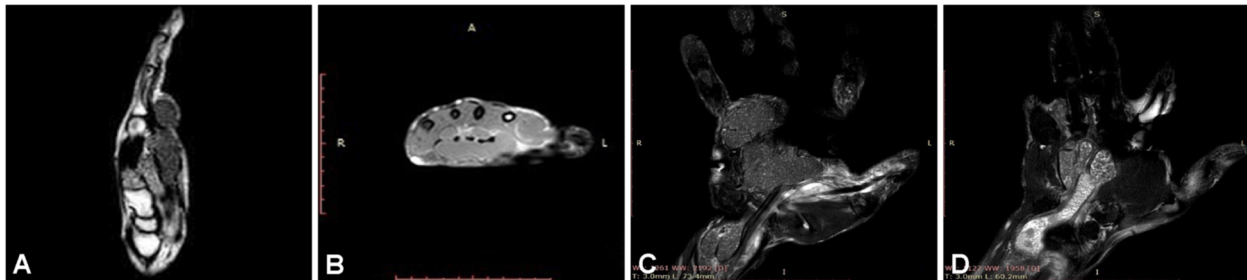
MRI aspect of Case No. 5: (A) heterogeneous mass with hyposignal on T2-weighted sequence; (B) T1-weighted sequence showing a mass with low signal intensity surrounding the flexor tendons; (C and D) Lobular, multiloculated, well-circumscribed mass with parietal contrast uptake harboring countless tiny areas with hyposignal on T2-weighted sequence around the flexor tendons, located at midpalmar level, around the superficial and deep flexor tendons, without modifying their signal, extending under the flexor *retinaculum* at the distal forearm extremity with a total length of 210 mm. MRI: Magnetic resonance imaging.
